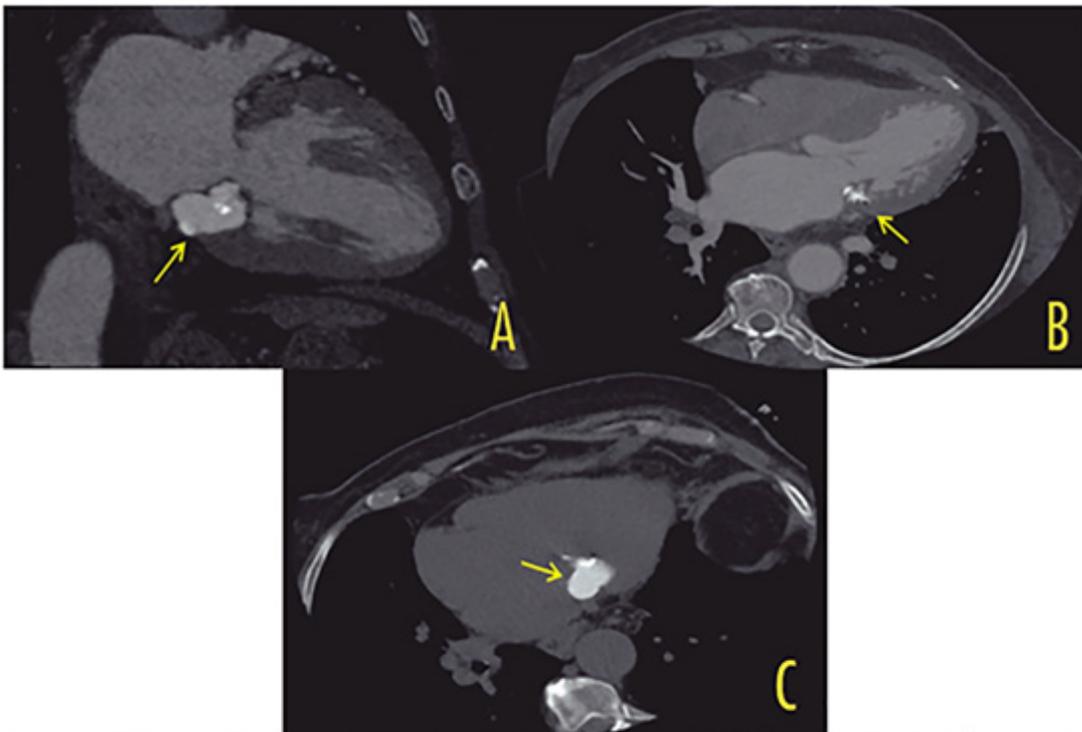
Cardiac computed tomography. A) Two-chamber view; B) Four-chamber view; C) Calcium score.
